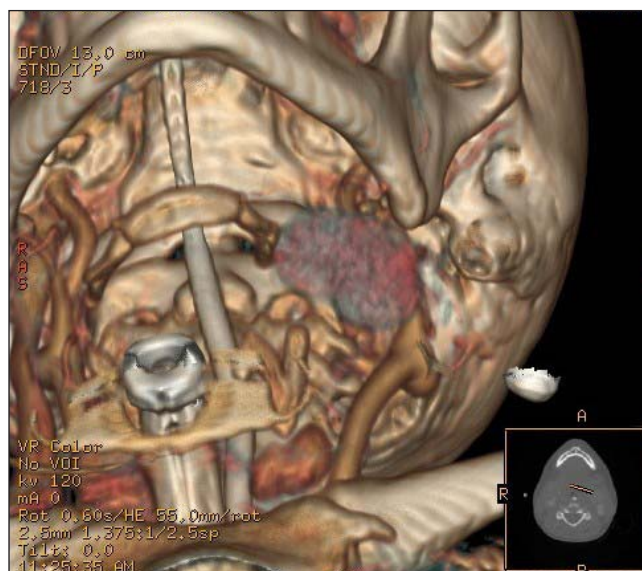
Three-dimensional reconstruction of the CT scan showing the pseudoaneurysm situated between the left external carotid artery and the hyoid bone.
